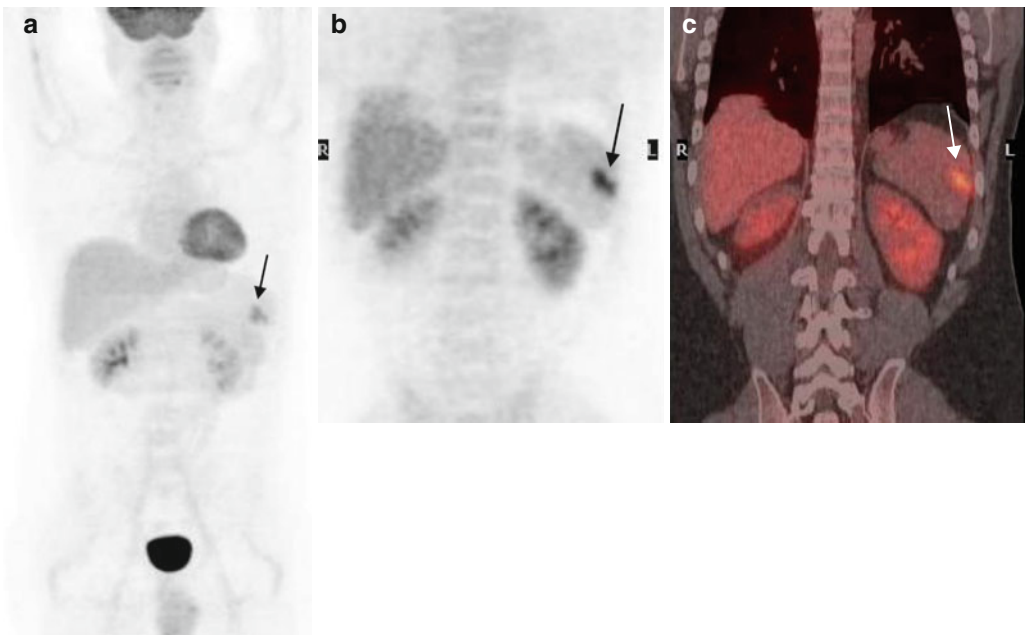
(a–c) MIP-PET and fused PET/CT – follow-up: Hypermetabolic lesion at the spleen (*arrows*)
